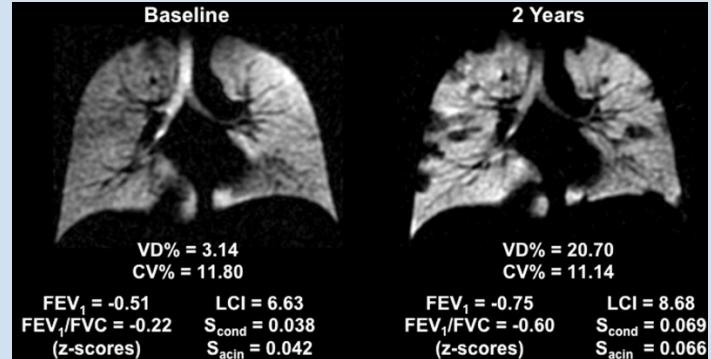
CF example subject. Baseline and 2 year follow-up ventilation MR images and corresponding lung function
